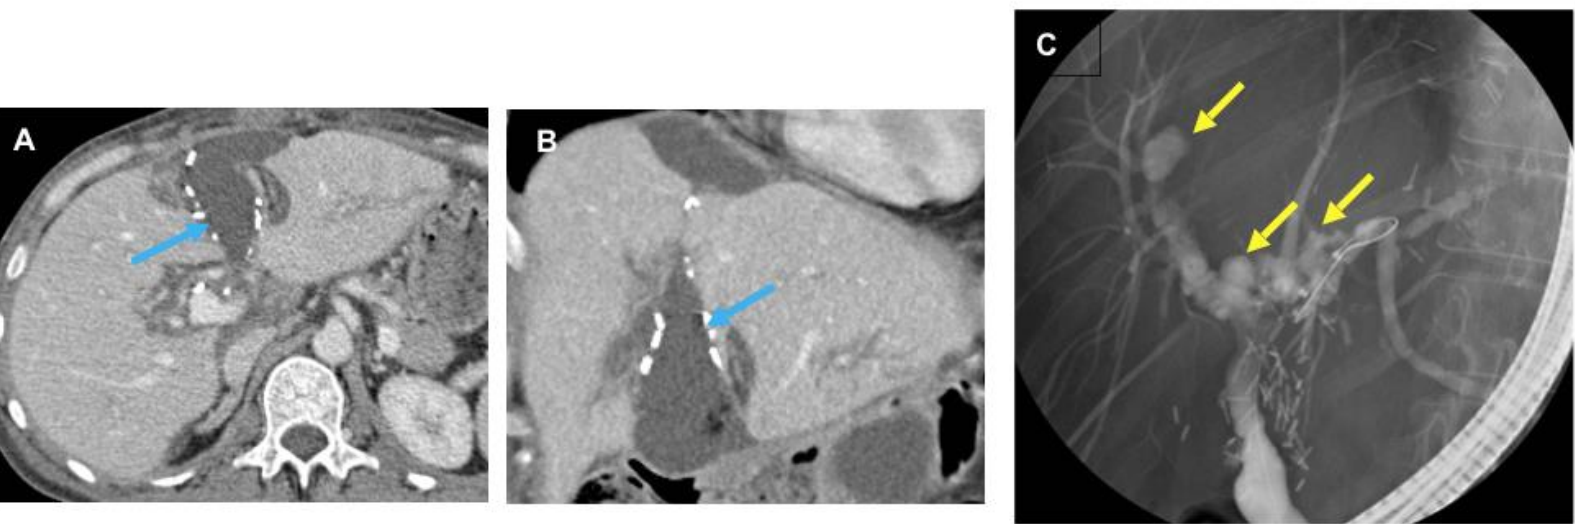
49 year old female underwent a liver transplant for primary biliary cirrhosis. Initial split liver converted to whole graft secondary to variant arterial anatomy. (A, B) Developed large biloma (blue arrows) at the site of the cut liver surface as seen on axial and coronal CT. Further complicated by ischaemic cholangiopathy secondary to hepatic arterial anastomotic stenoses seen on post operative doppler ultrasound and contrast enhanced CT. (C) Ischaemic cholangiopathy is demonstrated by central duct irregularity and multiple bilomas around the right and left hepatic ducts at ERCP communicating with the cholangiopathic ductal system (yellow arrows).
